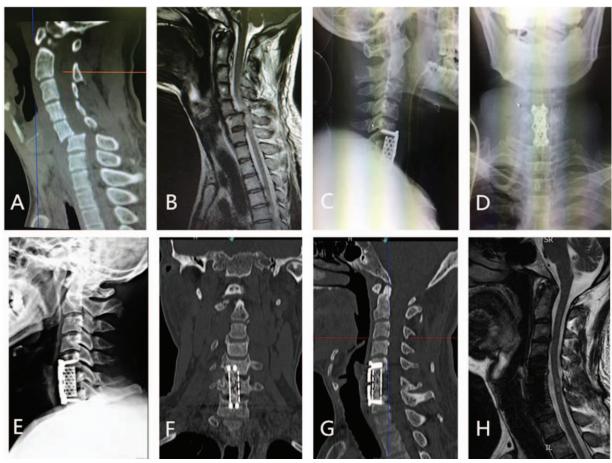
A 51-year-old male with C5-C6 fracture and dislocation caused by a traffic accident; Allen–Ferguson classification of distraction–flexion injury: degree III; preoperative Frankel score: C. ACCF was performed after reduction. (A) Preoperative sagittal CT images show C5 to C6 fracture and dislocation. (B) Preoperative MRI shows spinal cord compression due to C5 to C6 fracture and dislocation and disc herniation. (C, D) Postoperative anteroposterior and lateral radiographs were examined. (E) Lateral radiographs acquired 2 years postsurgery show normal physiocurvature of the cervical spine and disc space height. (F, G) CT reconstruction images obtained 2 years after the surgery show fusion of the grafted bones. (H) MR images were taken 2 years after the surgery show unobstructed spinal canal, good stability of the cervical spine, and fusion of the grafted bones.
